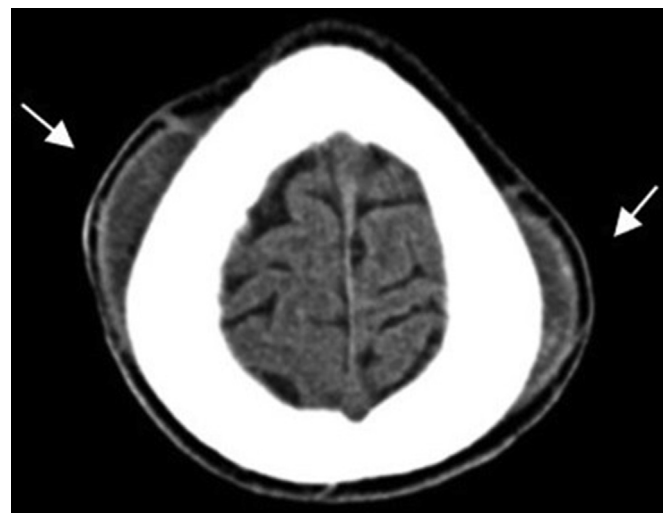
CT image of a 15-year-old male patient with SCD complaining of non-traumatic cranial bilateral swelling; axial images showing bilateral hypodense parietal epicranial collections (arrows) in a thickened skull. Due to severe chronic anaemia, blood collections in SCD patients, even in an acute phase, may present with low density.
